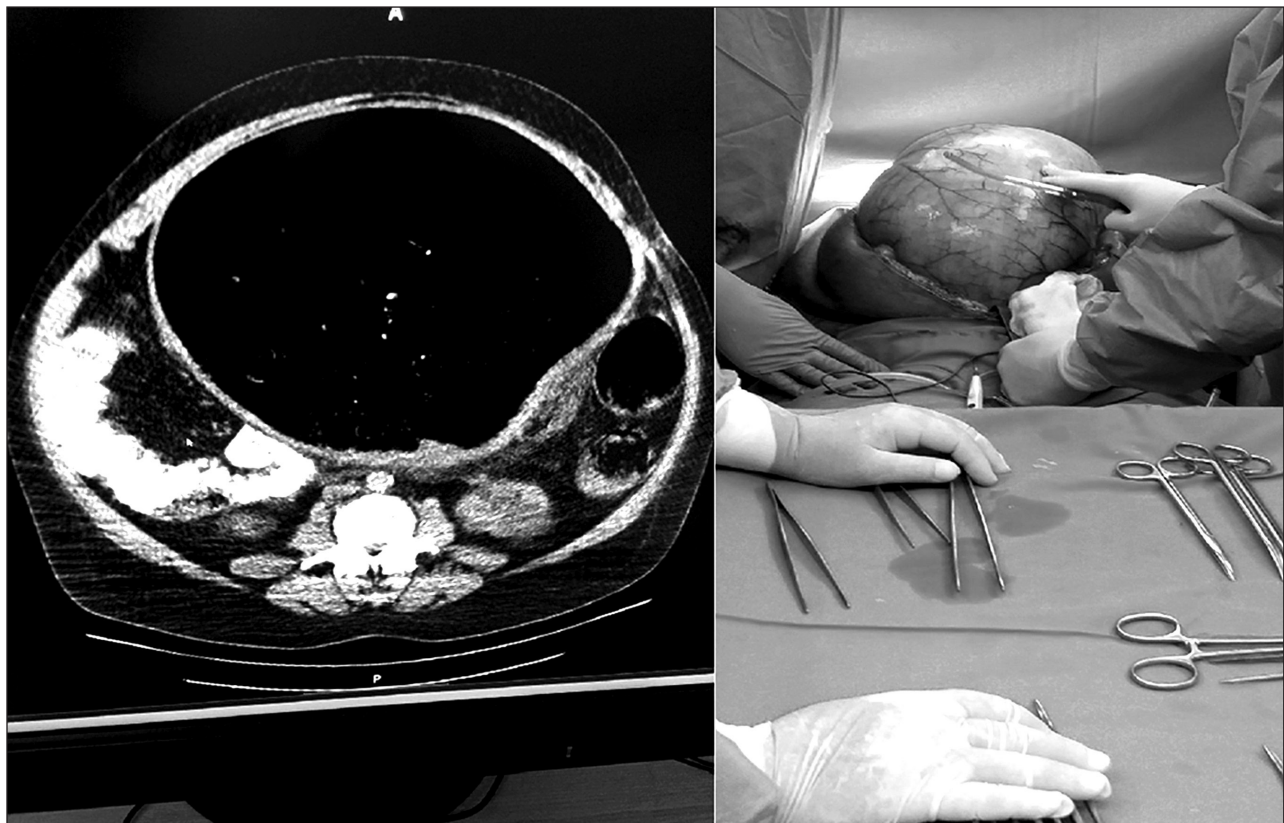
A) Computed tomography scan showing a 25 cm distension of the sigmoid; B) a view of the distended bowel during explorative laparotomy.
